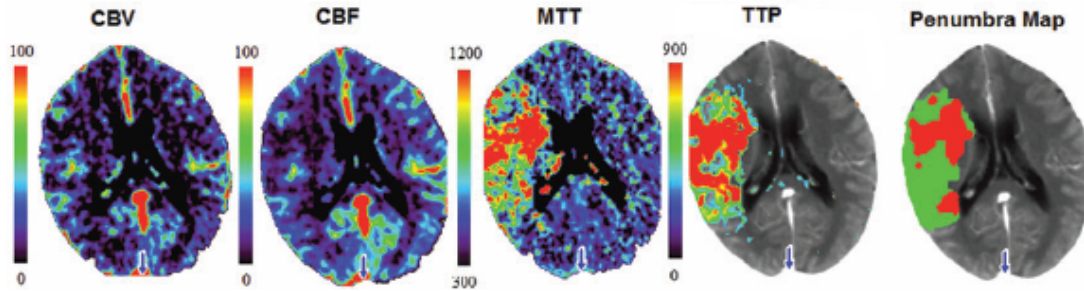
CT Perfusion maps: CBV, CBF, MTT and TTP. The penumbra map is a prediction map showing in red the estimated ischemic core and in green the estimated penumbra. Source: Bivard *et al.* [2]
